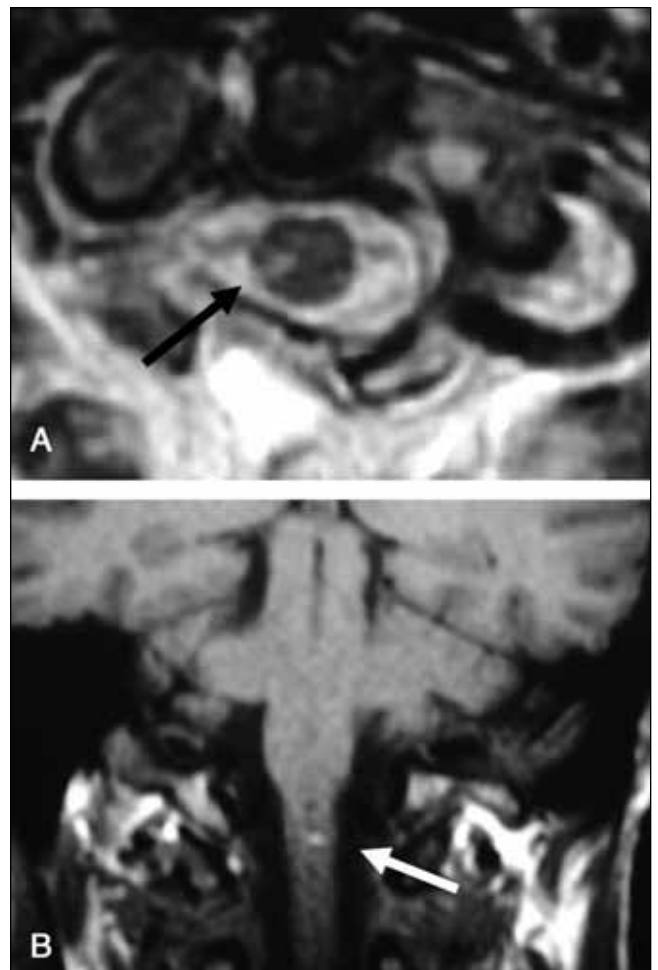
The T-2 weighted axial (A) and T-1 weighted coronal (B) magnetic resonance images showing the postoperative signal change in the cervical cord, representing edema and possible microhemorrhage at one of the ventrolateral partial rhizotomy lesion sites. The associated deficits were mild and the patient recovered
